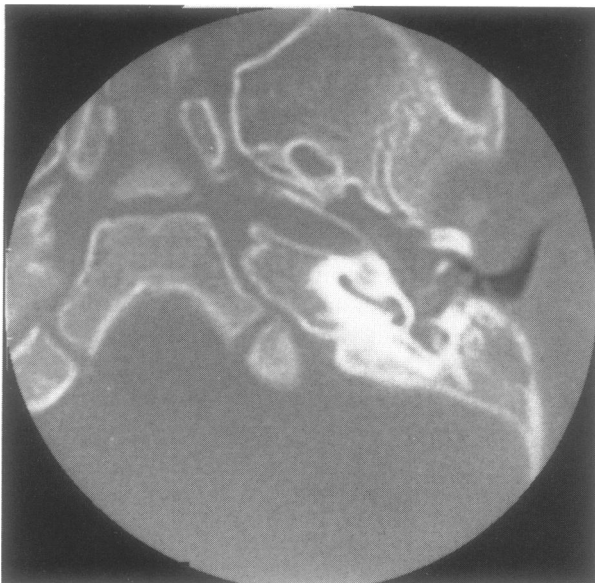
Magnified axial CT showing the proximity of the mass to the horizontal carotid canal, cochlear promontory, and foramen spinosum.
